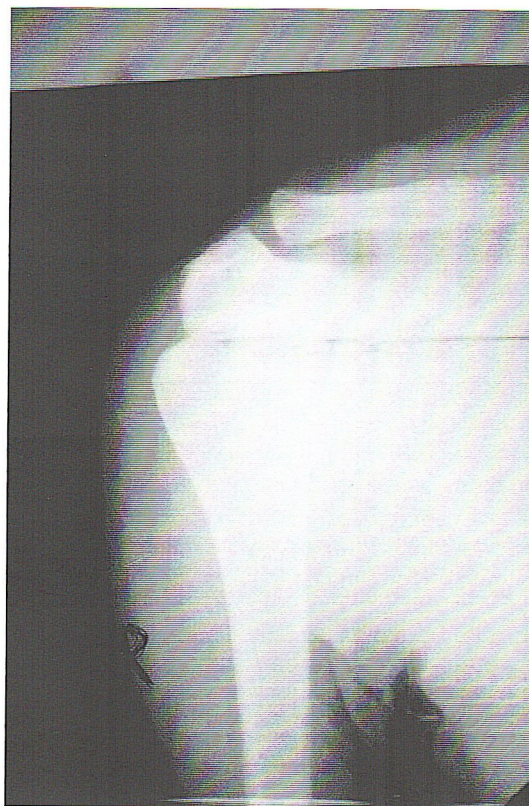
Shoulder joint X-rays: underage boy
